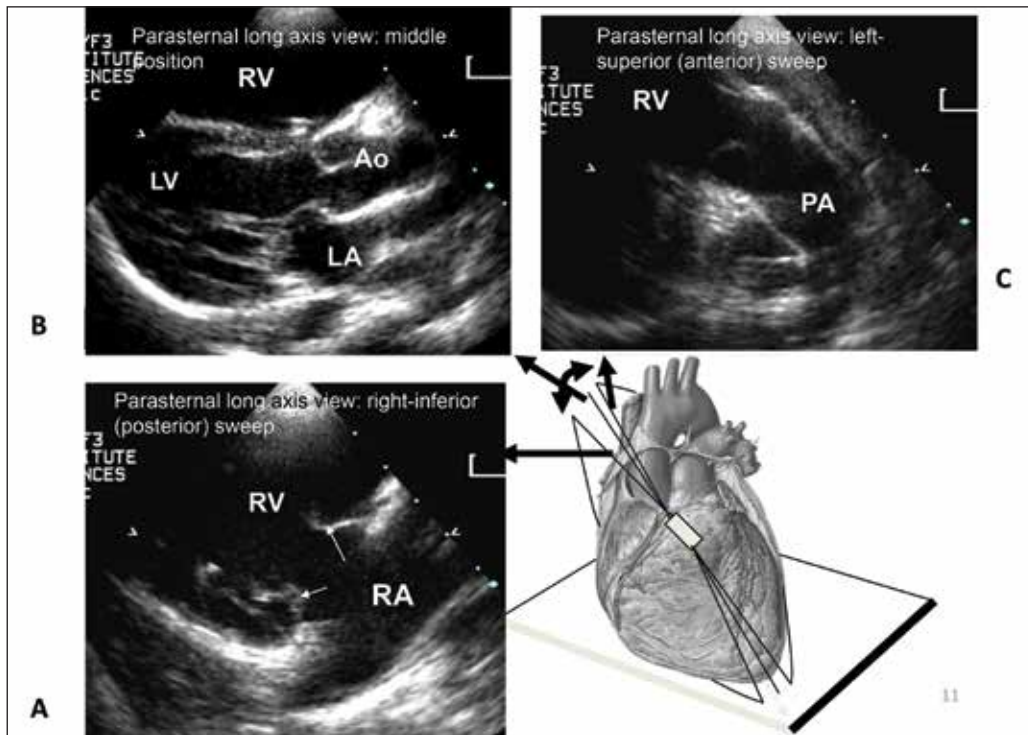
Transducer position and imaging planes for the parasternal long-axis views. The three images are obtained by sweeping rightwards and inferiorly (A) and leftwards and superiorly (C) from the standard parasternal long axis view (B).
